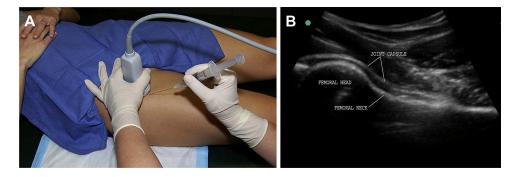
(A) Visualization of the hip is performed by placing the transducer firmly over the area of the femoral head-neck junction in the long axis and slightly oblique. A slightly oblique angle to the transducer allows a more lateral entry site for the needle into the joint and increases the distance between the needle and the femoral neurovascular structures anterior to the hip. The skin has been sterilely prepared, and sterile gel is used. Before the injection, a scan should be performed to visualize the location of the neurovascular bundle. (B) Ultrasound image of anterior hip joint with probe positioned over femoral head-neck junction as described earlier. © 2014 J. W. Thomas Byrd.
